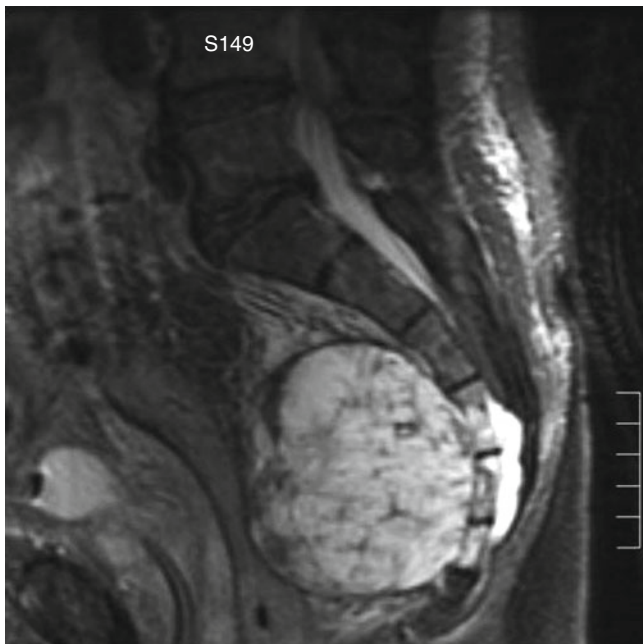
Typical MRI appearance of large sacral chordoma
